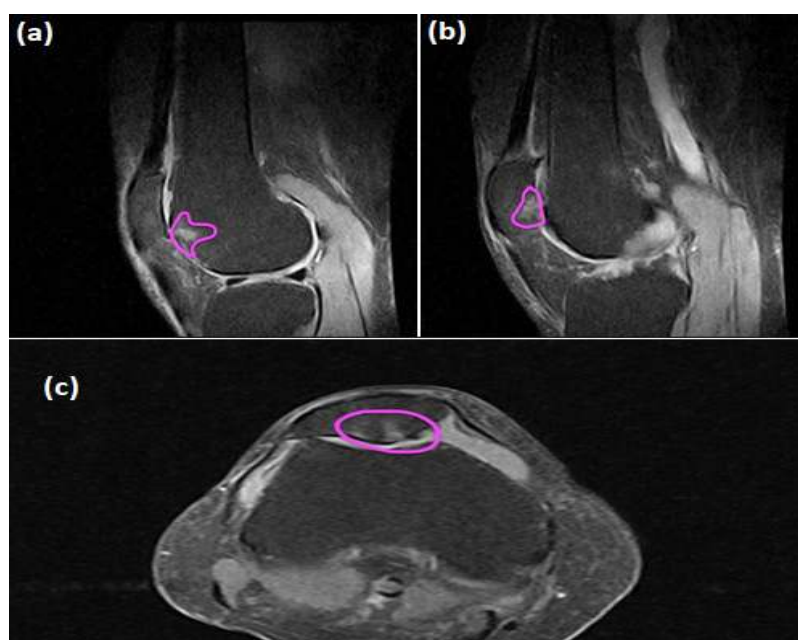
T2-weighted MRI sagittal (a, b), and axial images (c) of the right knee, taken on October 2021, demonstrated bone marrow lesions within the femoral condyle (a), and articulating surface of the patella (b, c); purple outline.
